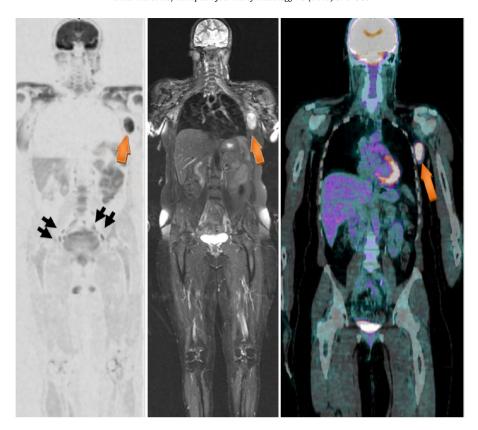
65 years old woman. DWI, STIR and PET-CT images are respectively depicted from the left to the right. The left axillar lymph node is well visualized by both MRI and PET-CT (orange arrows). Its size is around 25 mm. On the contrary, small bilateral iliac lymph nodes, whose size is 5–7 mm, are only displayed on DWI sequence (black arrows).
